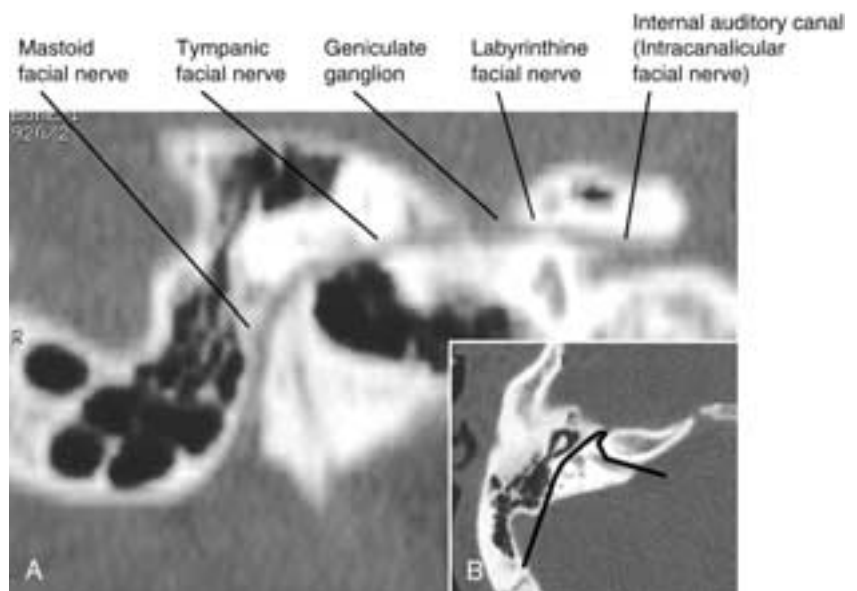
Curved coronal-sagittal CT reconstruction of the facial nerve. A, The facial nerve is seen from the IAC to the point where it exits the temporal bone at the stylomastoid foramen. B, The dark line represents the course of the curved surface in A.
